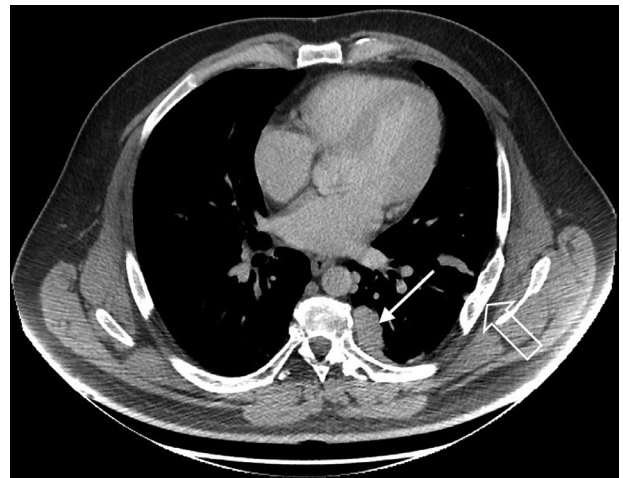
CT enhanced image, axial projection, displaying nodularity (solid arrow) of left pleura space and chronic deformity of an adjacent rib (open arrow) from prior trauma.
